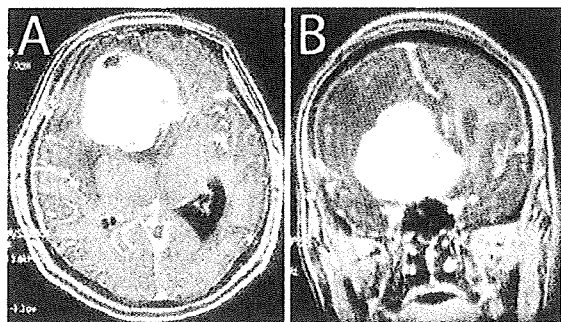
Axial (A) and coronal (B) gadolinium-enhanced T1-weighted MRI at presentation.
